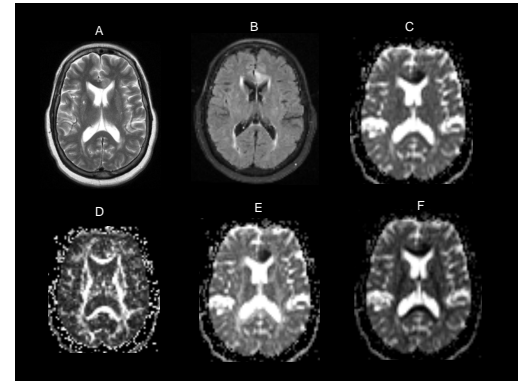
A: T2WI; B: FLAIR; C: ADC map; D: sRA map; E: Axial diffusivity map; F: radial diffusivity map. The above graph shows a case suffered from a left anterior cerebral artery (ACA) infarction.
